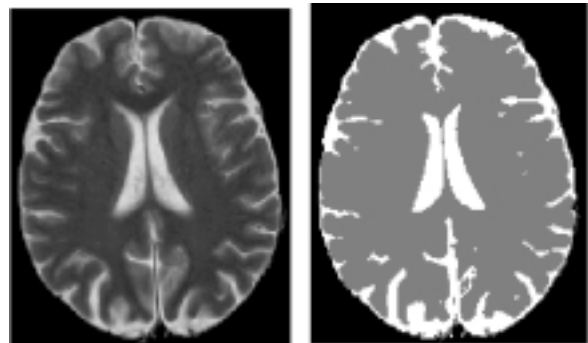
(a) T2-weighted image of mild atrophy after dura and background were removed. (b) Segmented image by the *ISM* algorithm.
